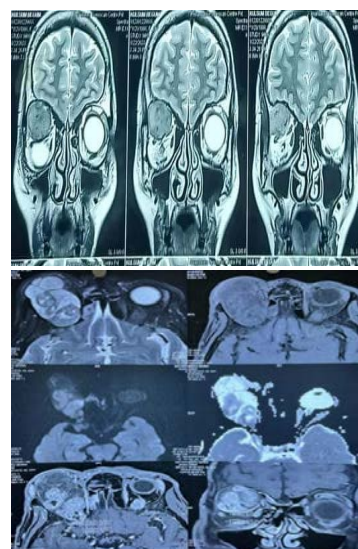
MRI Images of Right Orbital Tumours
